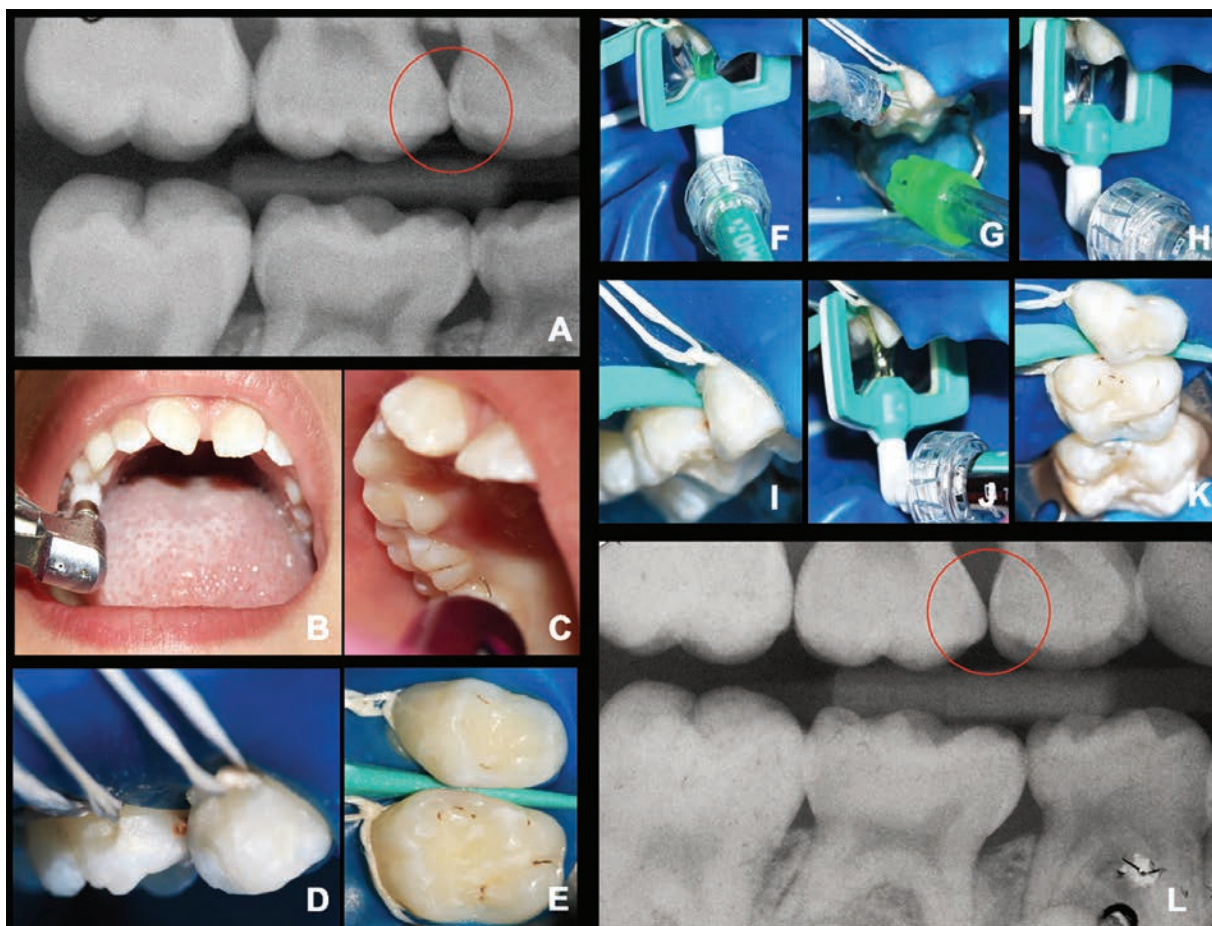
Resin infiltration technique on teeth 54 and 55 ICDAS 4. A) initial interproximal radiograph (bite wing); B) Prophylaxis of the teeth using prophylactic paste; C) Interpapillary anesthesia (lidocaine 2% + epinephrine 1: 100,000); D) Isolation with rubber dam; E) Separation wedge provided in the kit inserted into the interproximal region of elements 54 and 55; F) approximal matrix, attached to the Icon-Etch syringe, introduced with the green face of the arch and the pores facing to the surface of the proximal lesion to be treated; G) Removal of the gel with water and air jets; H) Icon-Dry syringe; I) approximal region; J) Icon-Infiltrant syringe fitted into the proximal region; K) Dental floss was used to remove the excesses of the material; L) Interproximal radiography after 3 months follow-up showing the filling of the cavity by the resinous infiltrate (Icon).
